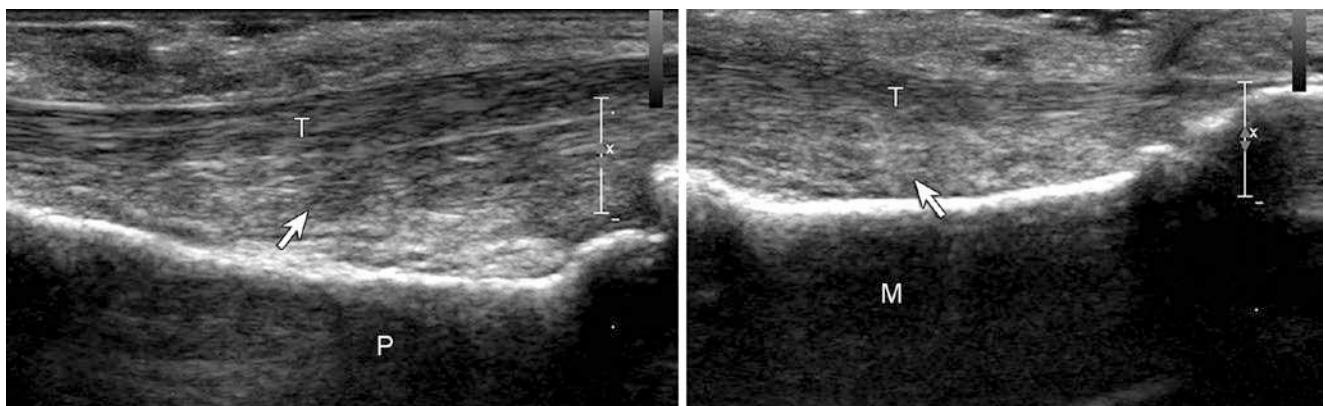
Pulley injury. Ultrasound image long axis to the flexor tendons (T) of the finger shows abnormal volar displacement or bowstringing of the tendons (arrows) opposite the proximal (P) and middle (M) phalanges indicating A2 and A4 pulley tears, respectively
